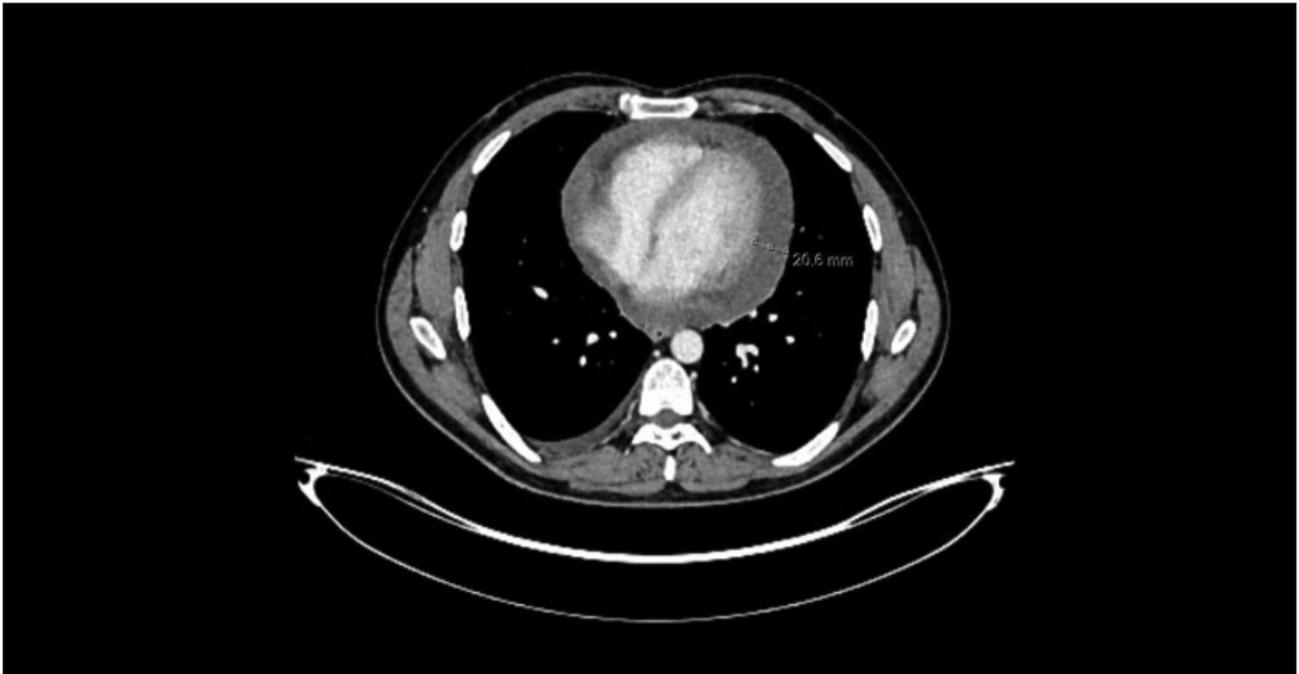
Computed tomography of the chest revealed a pericardial effusion with a maximal thickness of 20.6 mm.
